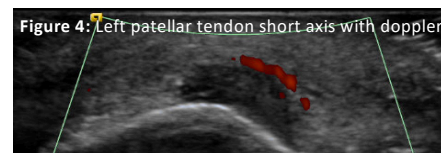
Left patellar tendon short axis with doppler
